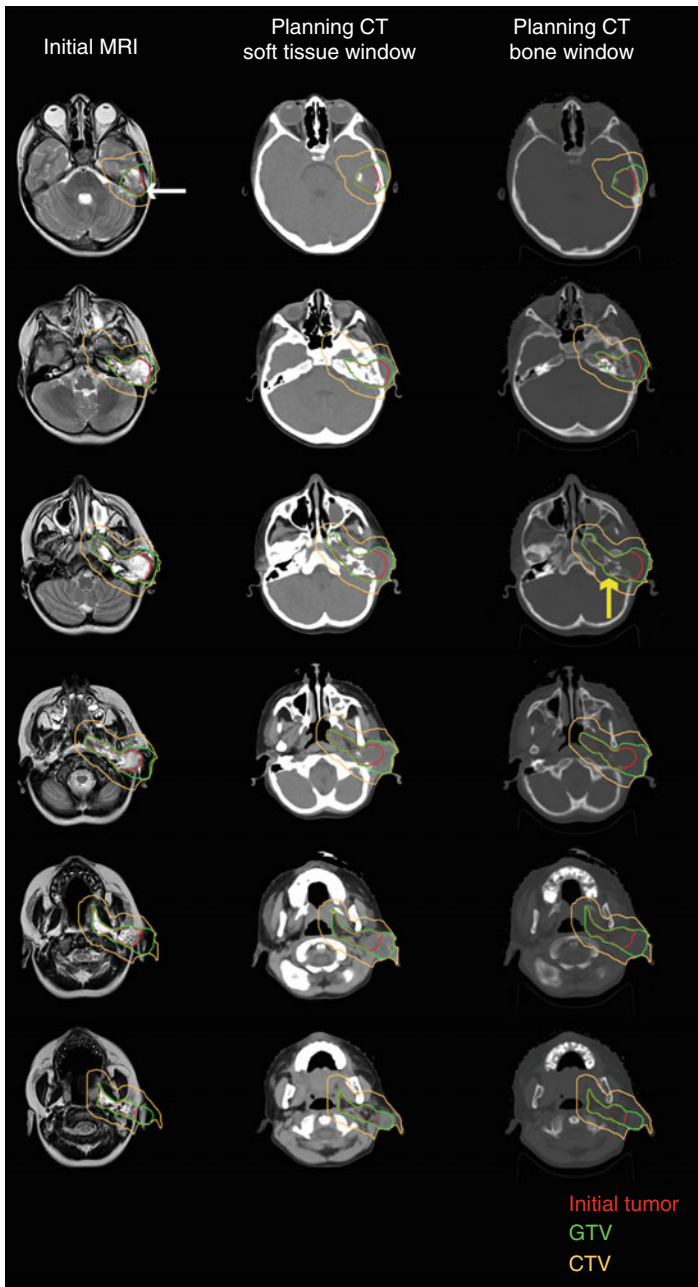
A patient with rhabdomyosarcoma involving the middle ear. The initial tumor (as defined by the MRI), GTV, and CTV are shown on the initial MRI and planning CT (both bone and soft tissue windows). The patient has intracranial extension (*white arrow*) and significant bony destruction of the middle ear (*yellow arrow*)
